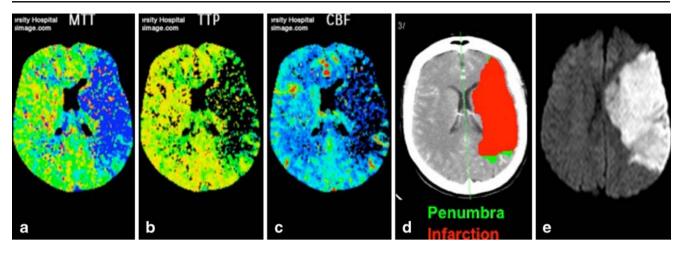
Patient with massive left hemispheric stroke but no penumbra: There is a match between MTT TTP and CBF maps; the penumbra map shows almost no tissue at risk and only infarction. On the follow-up DWI, this large MCA infarction is confirmed
